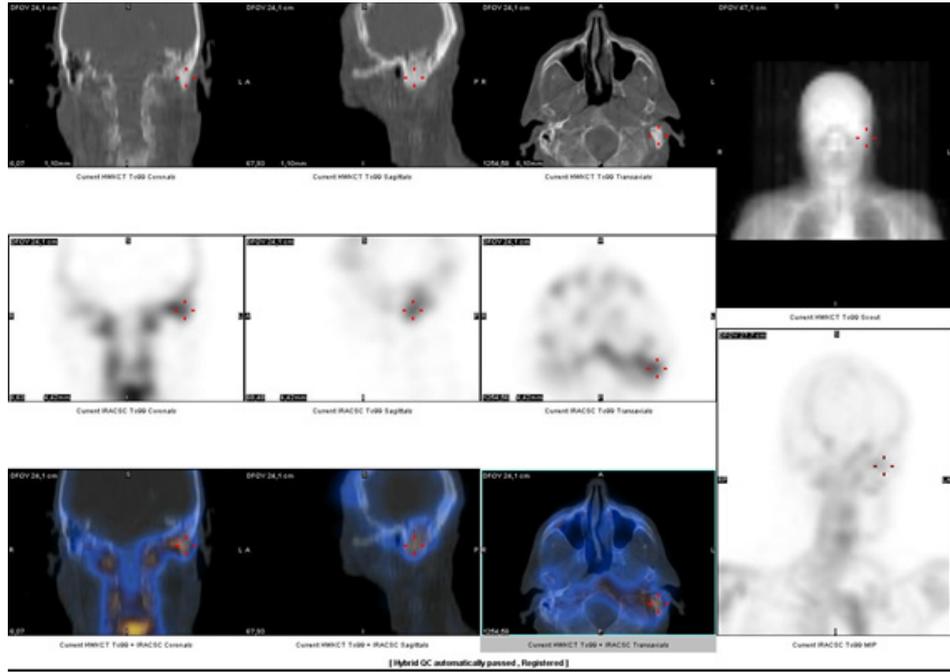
Body scintigraphy with $[^{99\text{m}}\text{Tc}]$ Tc-MDP - Tomographic study.
